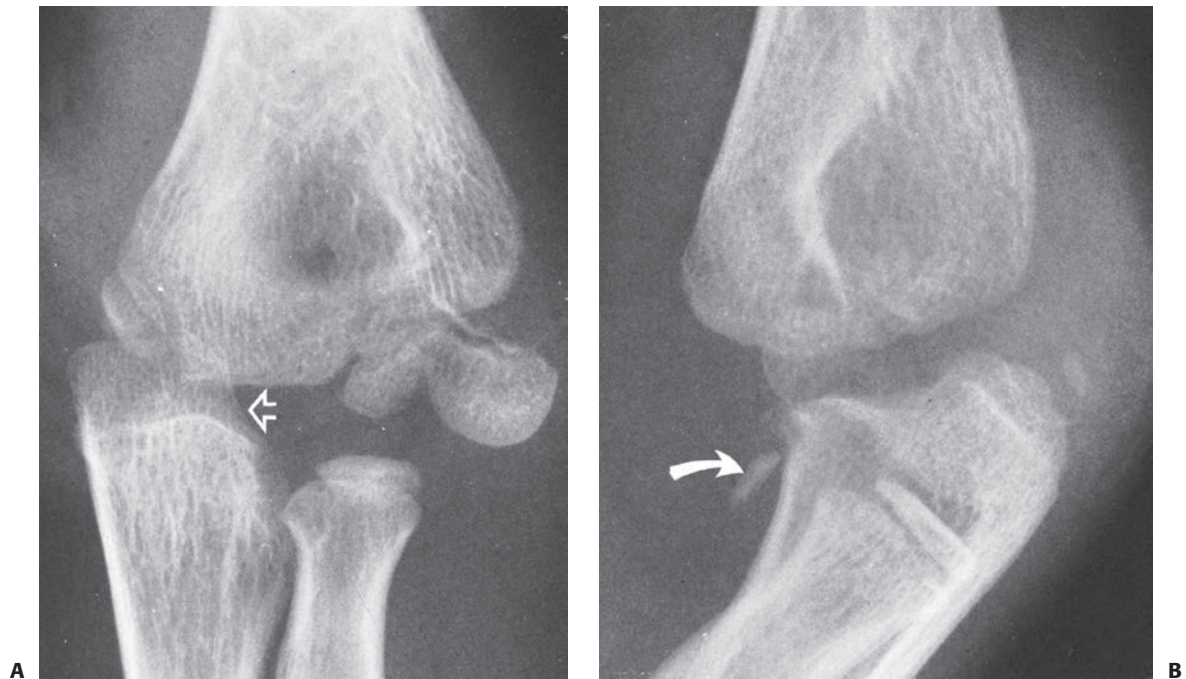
Ipsilateral injury. A: AP radiograph of an 8-year-old boy with a true posteromedial elbow dislocation (*open arrow*) and a lateral condylar fracture. B: A small fracture of the coronoid process of the ulna (*closed arrow*) confirms the primary nature of the elbow dislocation on the lateral radiograph.
